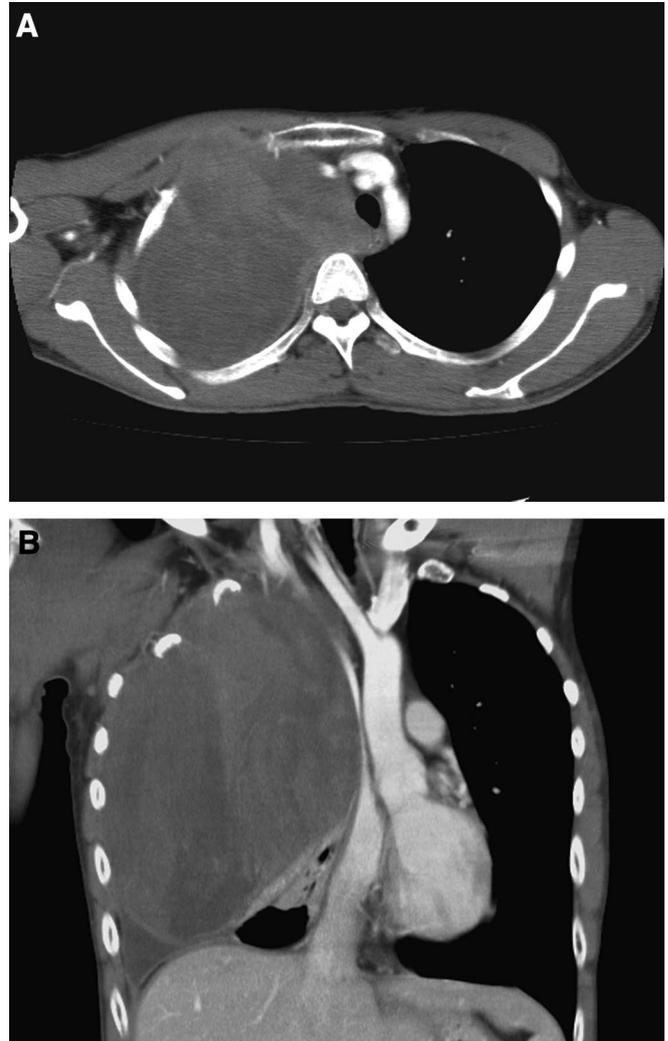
Computed tomography scans of the chest. A, Axial image. B, Coronal image.
